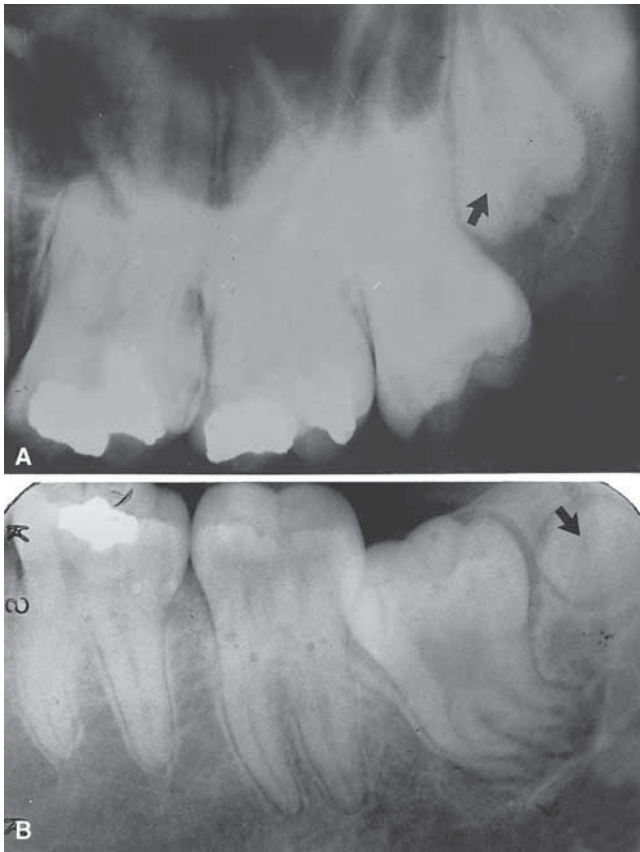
Paramolars, distomolars, or fourth (supernumerary) molars. A. Radiograph showing a maxillary (fourth) distomolar. B. Mandibular (fourth) distomolar just distal to the permanent third molar.
